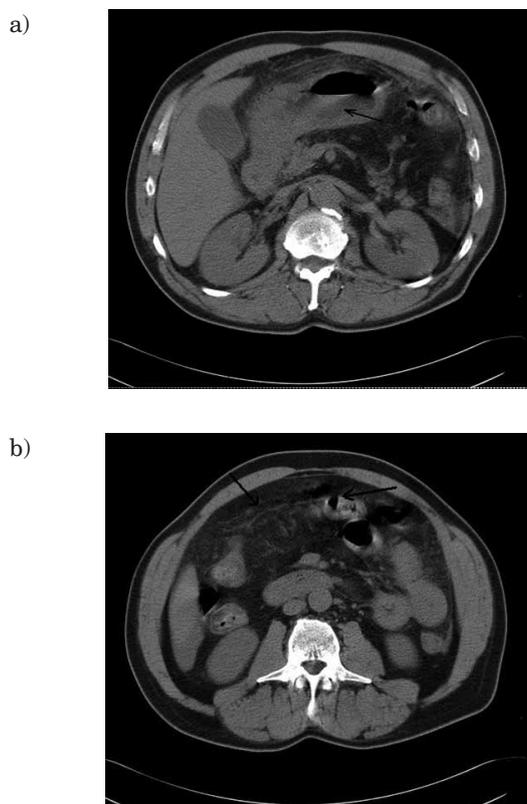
a) Urgent CT scan showed thick edematous gastric wall in antral region, b) CT scan: signs of peritonitis due to duodenal perforation.
